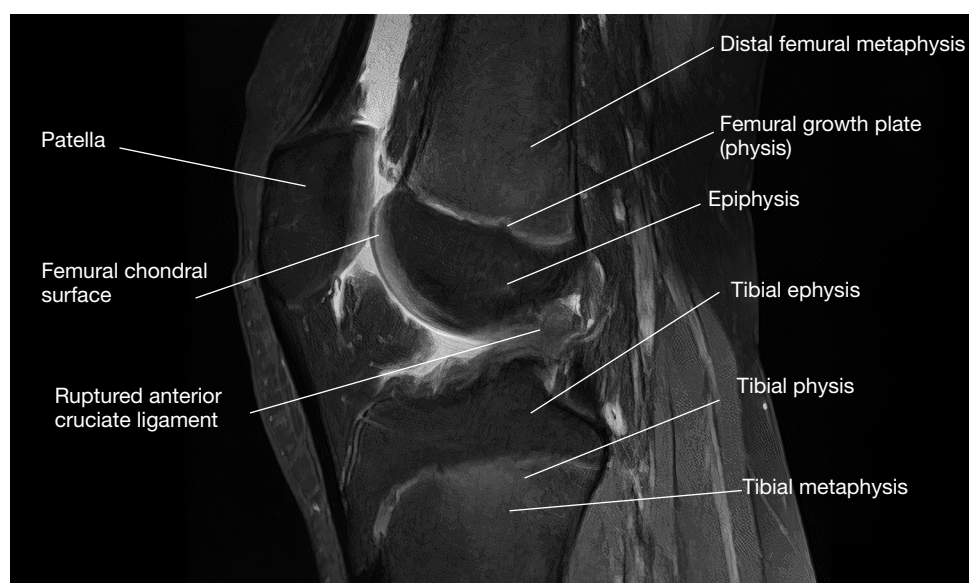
Annotated magnetic resonance image of anterior cruciate ligament tear.
